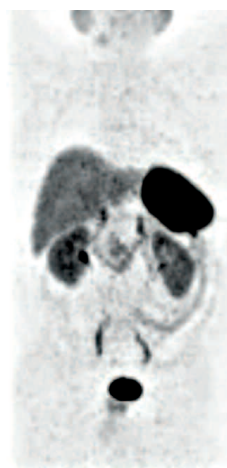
A case of MTC post thyroidectomy with modest and stable rise of calcitonin to 80pg/mL over 2 years and small volume right cervical nodes on US and CT. ^{68}Ga -Dotatate PET/CT MIP did not show significantly high uptake in cervical nodes or elsewhere. FNA of a left cervical node was negative.
